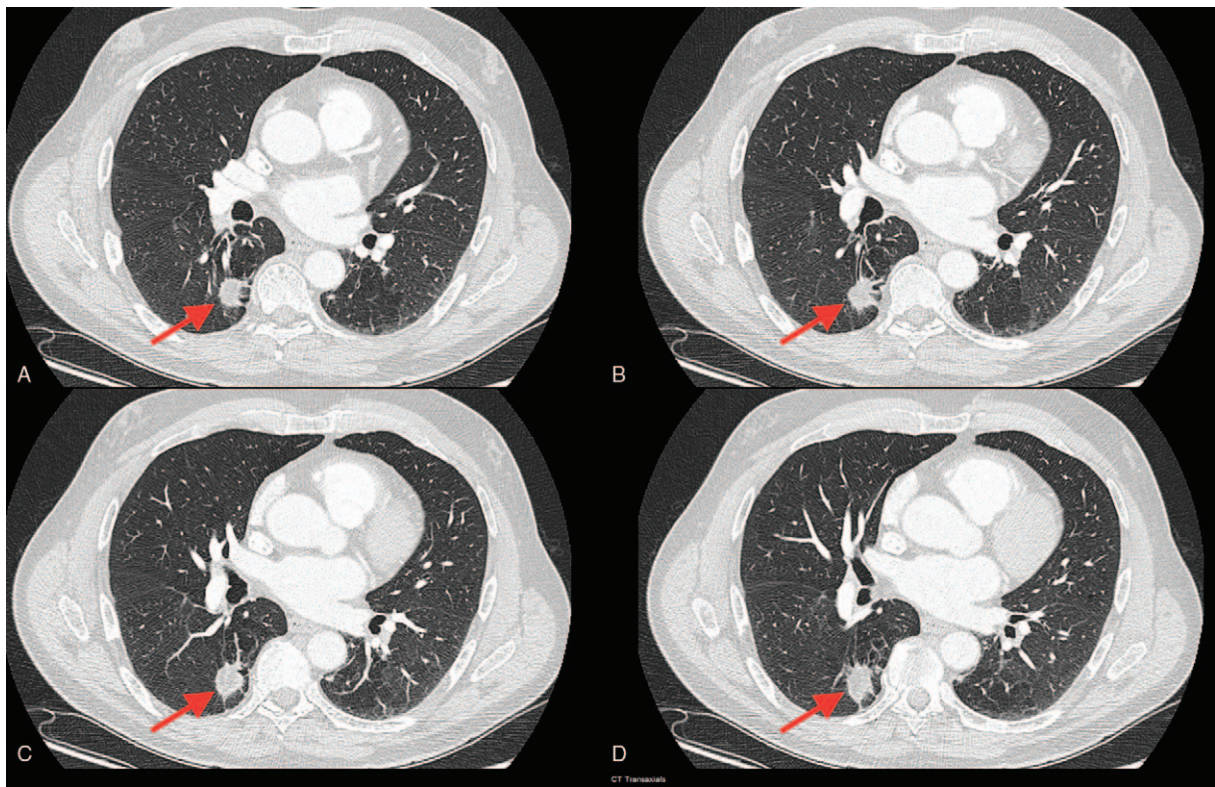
Chest HRCT revealing the pulmonary nodule had irregular borders (red arrow on sub-images A–D). HRCT = high-resolution computed tomography.
